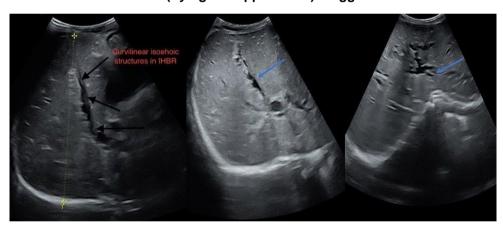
(A-C).Ultrasound images show hepatomegaly, dilated intrahepatic bile ducts with multiple strictures and internal curvilinear isoechoic structers (Ascaris)
